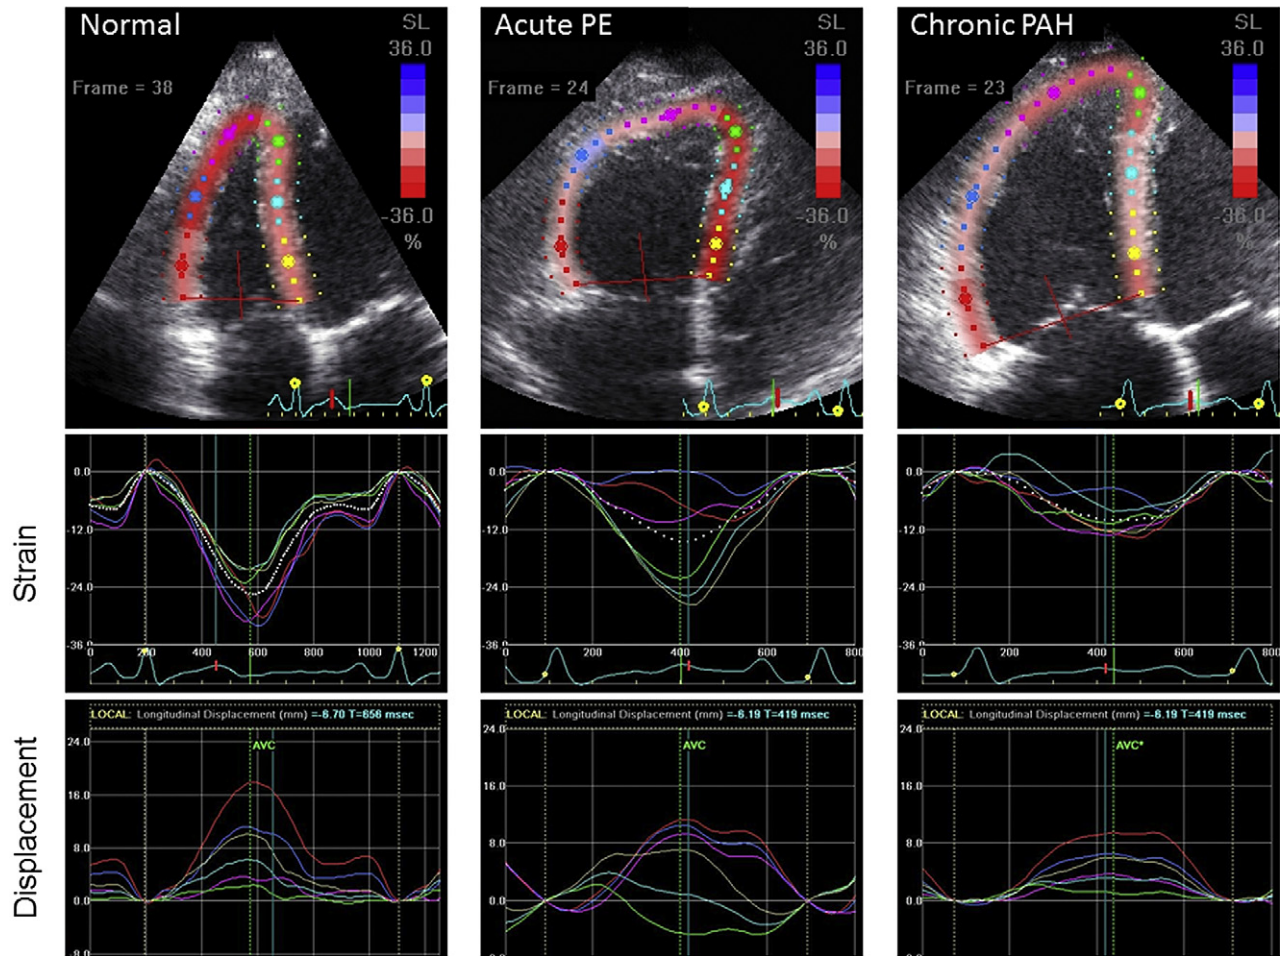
Examples of RV strain imaging in the RV-focused apical four-chamber view (*top*) and corresponding time-strain (*middle*) and time-displacement (*bottom*) curves from a normal subject (*left*), a patient with massive APTE (*middle*), and a patient with severe CPAH (*right*).
